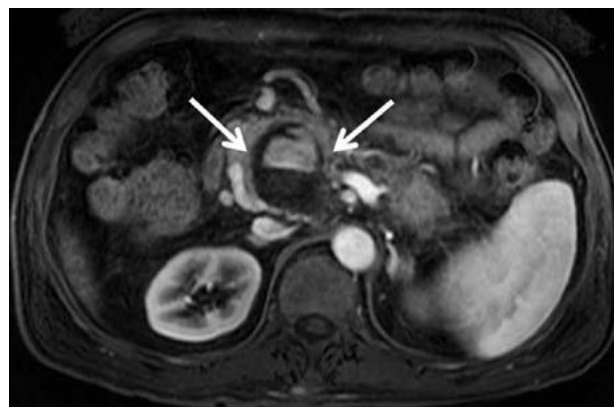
Biliary and pancreas dynamic T1-weighted axial MR image shows a contrast-filled pseudocyst of about 4.4x3.8cm at the pancreas head portion, which is suspected to be a hemorrhagic pseudocyst (arrows).
